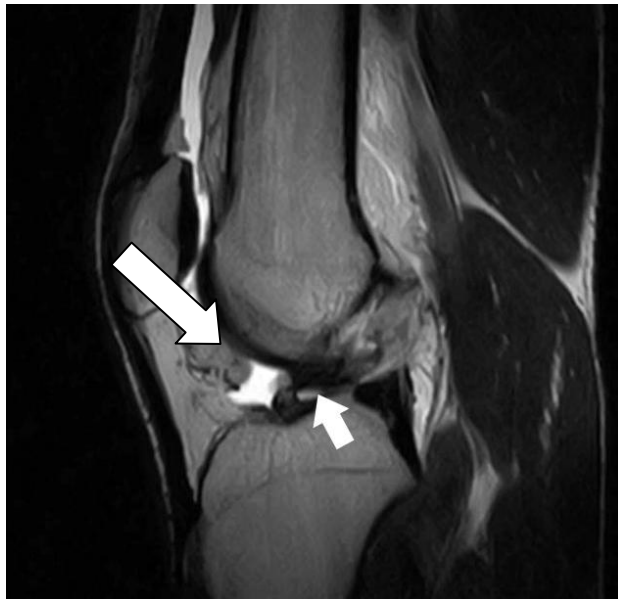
Sagittal T2-weighted magnetic resonance imaging (MRI) of ruptured anterior cruciate ligament (ACL) pointed by white arrow.
